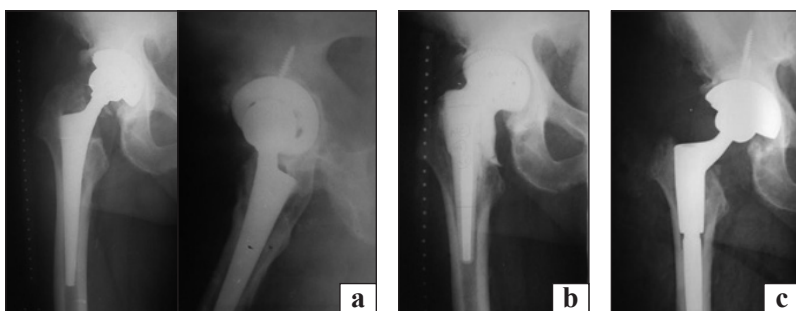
Patient S. Radiographs “before” and “after” surgical interventions: periprosthetic infection of the right hip joint (a); after revision of the joint, installation of a cement spacer (b); after revision arthroplasty (c)
